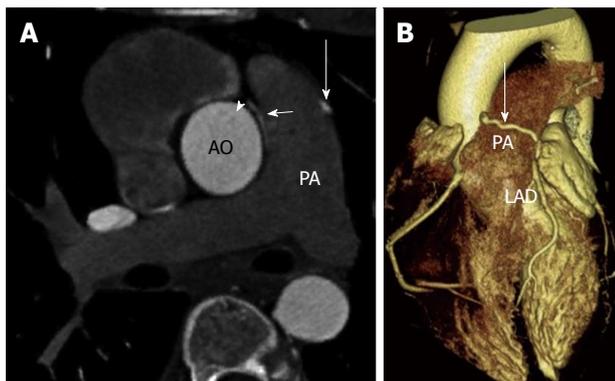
Coronary to pulmonary artery fistula. A: Axial contrast enhanced coronary computed tomography angiography shows left anterior descending (LAD) artery (long arrow) and right coronary artery (arrowhead) fistulas draining into the pulmonary artery. A jet of contrast (short arrow) is seen emptying into the pulmonary artery; B: Three-dimensional volume rendered computed tomography image shows the LAD coronary artery crossing anterior to the pulmonary artery (PA) to drain into it. AO: Aorta.
